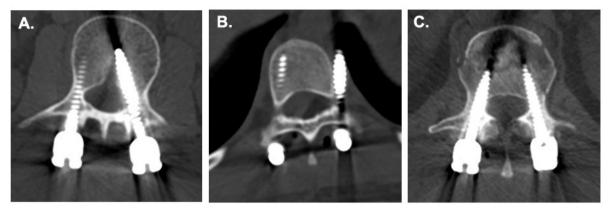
Post-operative CT image from the axial view of the case with medially (A) and laterally (B) misplaced of pedicle screw, and the case without (C) misplacement of pedicle screw.
